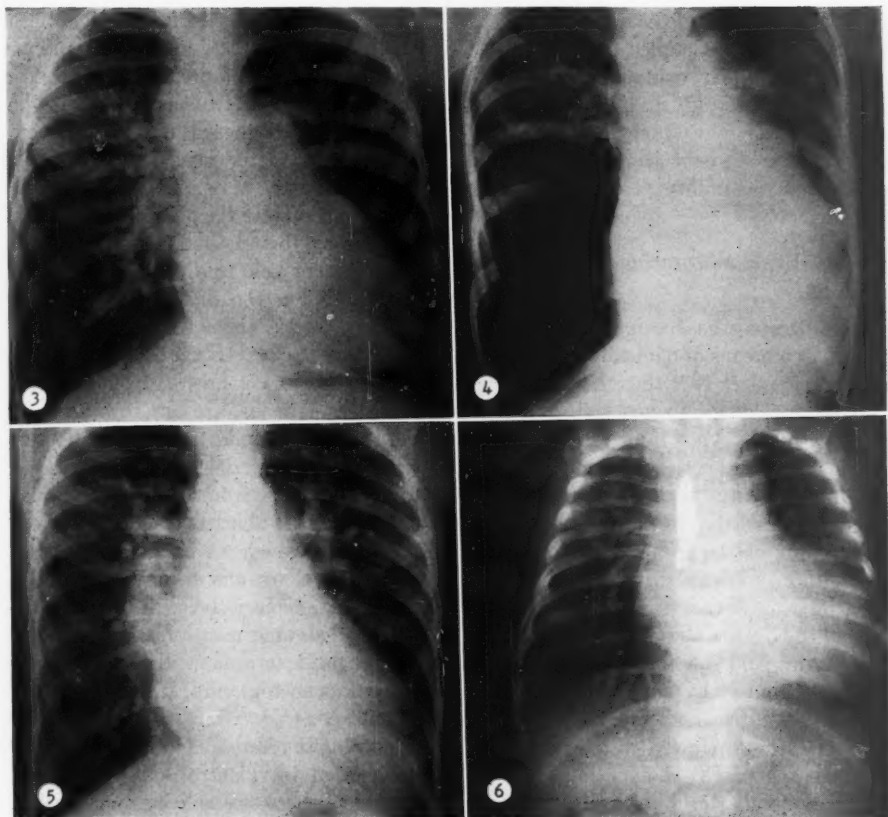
Roentgenogram of chest in case 3. Posteroanterior view. Age 8 years. Note right aortic arch.
